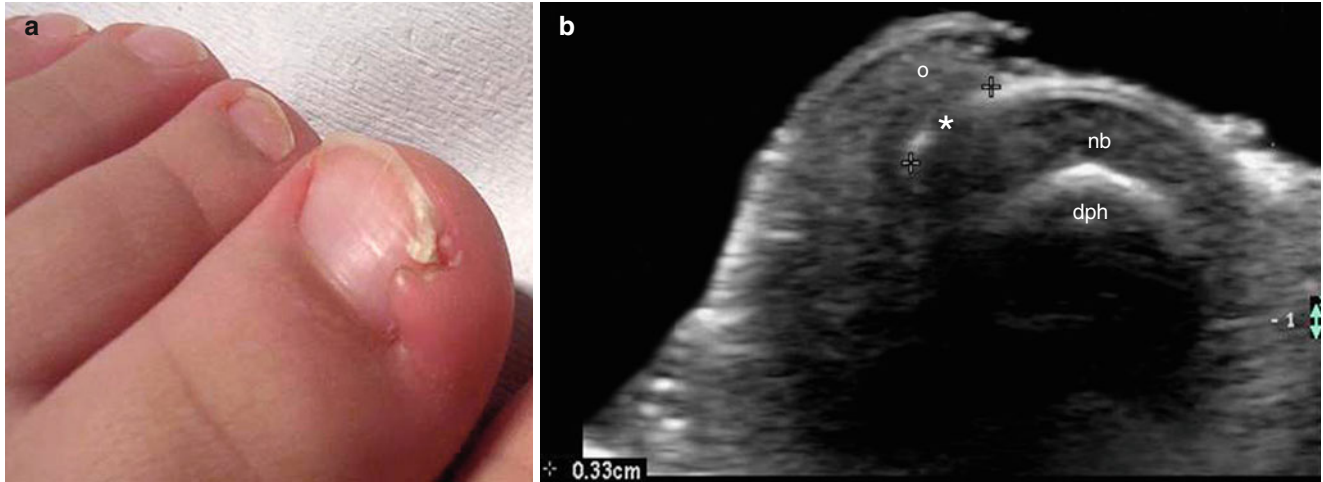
(a, b) Congenital hypertrophic lip of the hallux. (a) Clinical image shows erythematous and hypertrophic swelling in the medial nail fold of the left hallux. (b) Grey scale ultrasound image (transverse view) shows hypertrophy of the dermal layer (o) in the medial nail fold.
